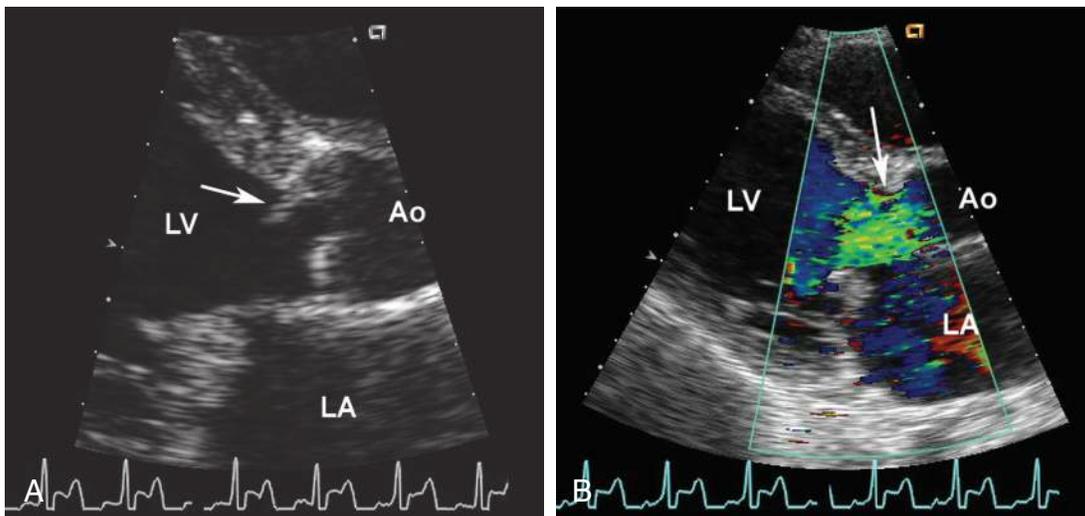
Endocarditis Resulting in Acute Severe Aortic Regurgitation. In a long-axis view of the aortic valve (A), a flail aortic valve leaflet is seen (arrow), with the leaflet (arrow) prolapsing into the left ventricular outflow tract in diastole. Color-flow Doppler imaging (B) in the same view shows a broad jet of diastolic flow filling the outflow tract, consistent with severe regurgitation. Ao, Aorta; LA, left atrium; LV, left ventricle.
